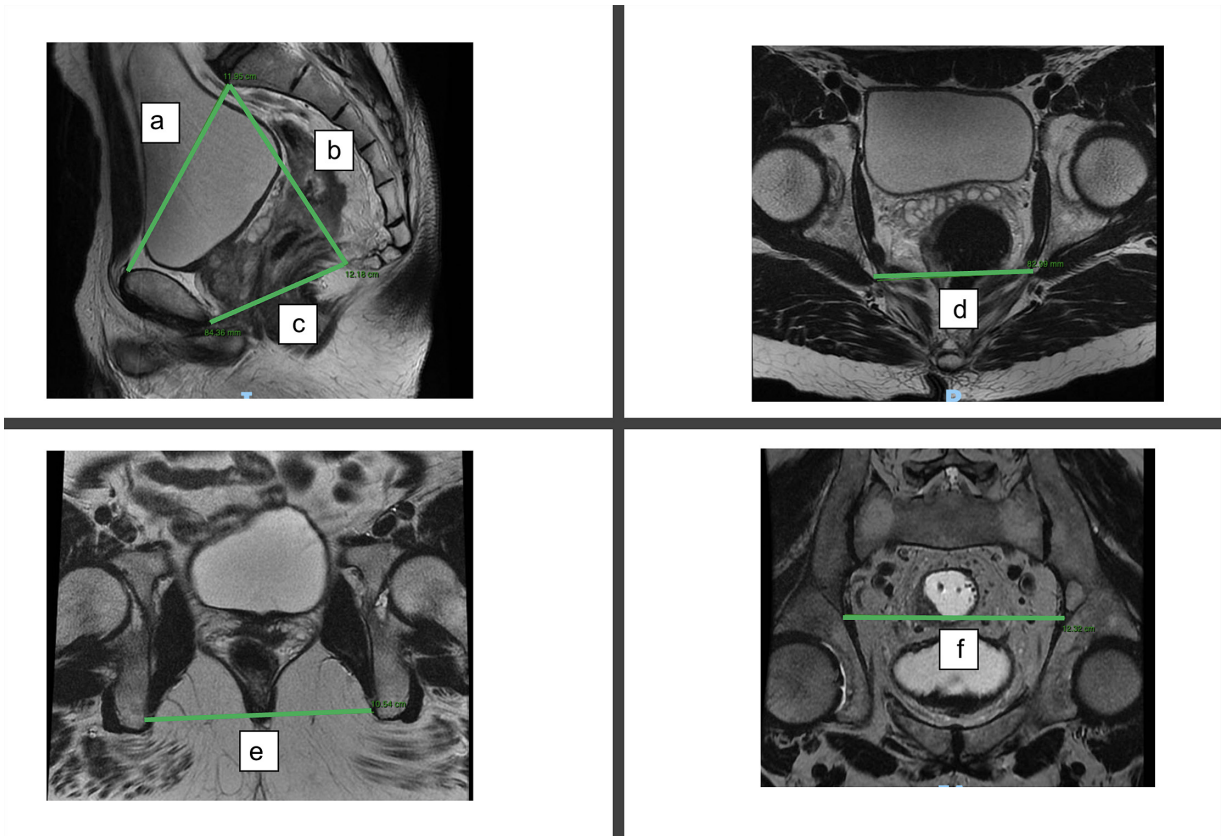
Magnetic resonance imaging (MRI) scan showing pelvimetric measurements.
